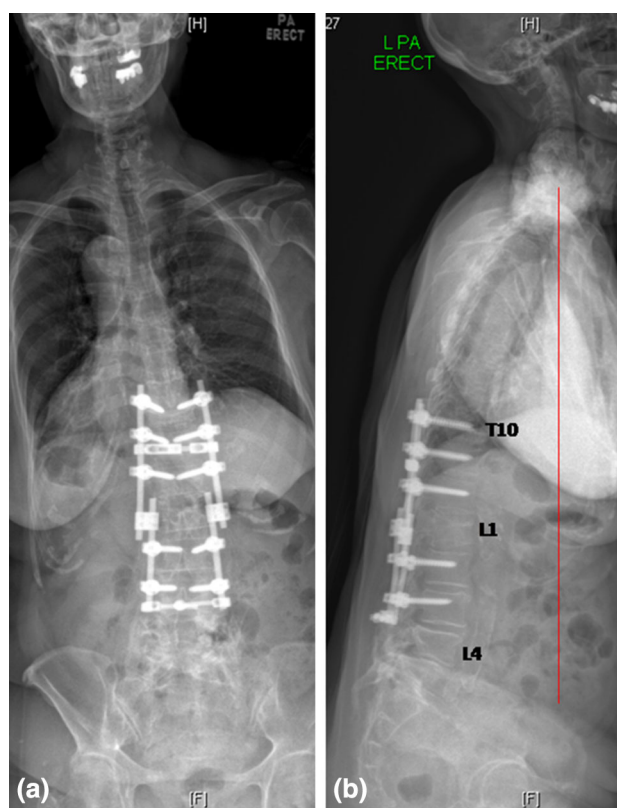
Erect whole spine radiographs using EOS technology. EOS® X-rays (EOS imaging, Paris, France) of the spine showed a Sagittal Vertical Axis (SVA) of +13 cm, pelvic incidence (PI) of 70°, lumbar lordosis (LL) of 16°, and a pelvic tilt (PT) of 44°
